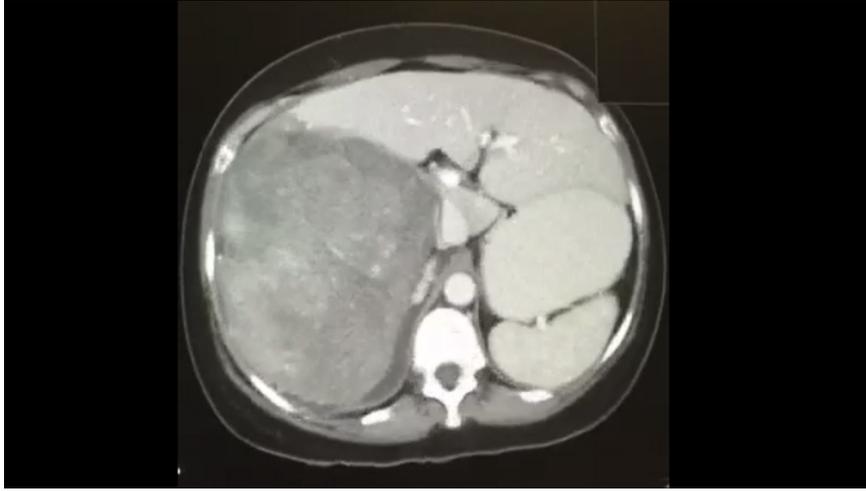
Contrast CT appearance of Adrenal Mass Showing Heterogeneity
